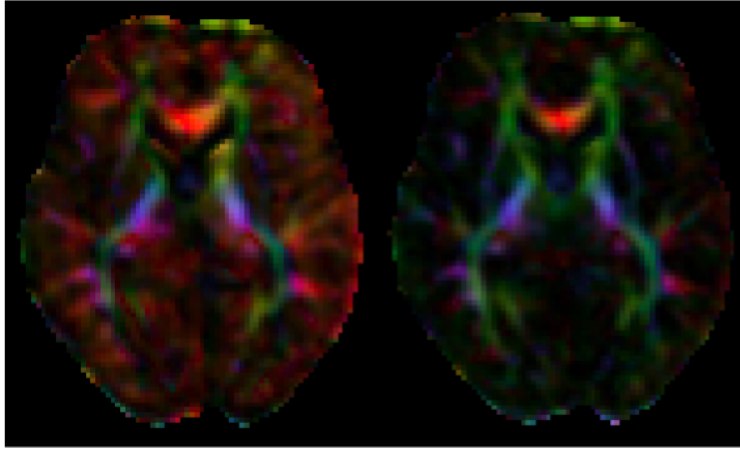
Demonstration of artifacts introduced when the intensity values of the DWI are not recomputed after warping. Left image: color representation of tensor maps computed from DWI whose intensity values were not recomputed after registration. Right image: the same, but with DWI intensity values properly recomputed. The background bias (red in color image) seen on the left image seems to indicate preferential diffusion in the x-direction. The background artifacts disappear when appropriate correction is used.
